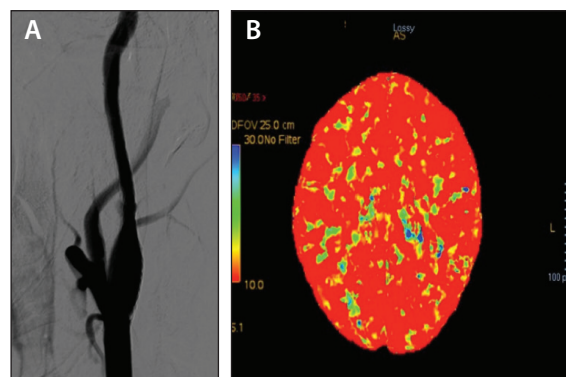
Final angiographic result (A). Follow-up perfusion CT scan showing no ischemic defect (B).
